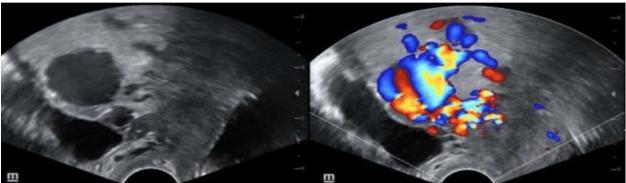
Placental lacunae, defined as the presence of numerous lacunae, often containing turbulent flow visible on grayscale or color Doppler ultrasound.
